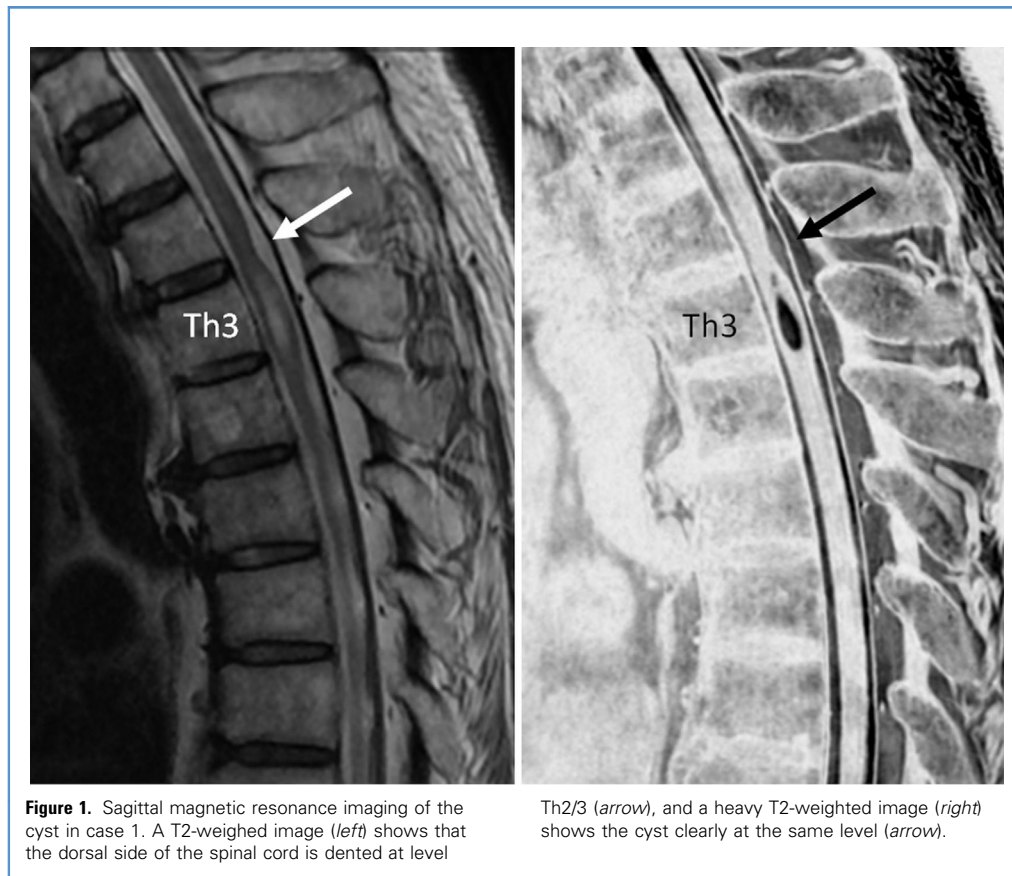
Sagittal magnetic resonance imaging of the cyst in case 1. A T2-weighted image (left) shows that the dorsal side of the spinal cord is dented at level
